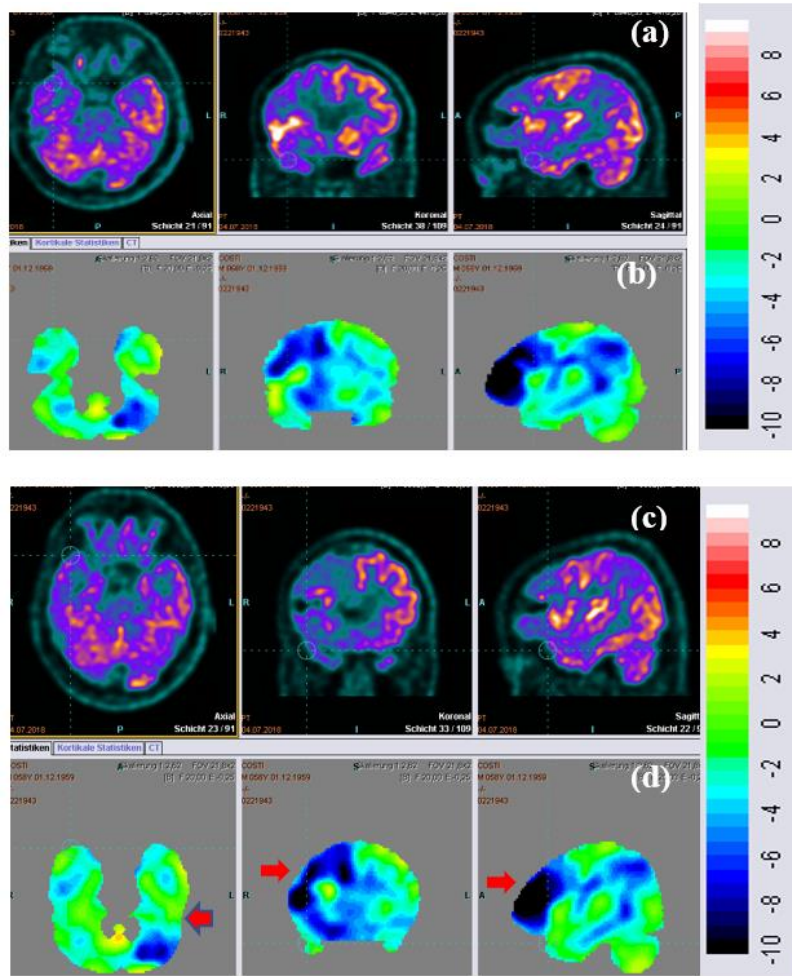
(a) Axial, coronal, and sagittal PET views with attenuation map obtained with nMC-CT attenuation correction, (b) scenium analysis nMC-PET, (c) axial, coronal, and sagittal PET views reconstructed with MC-CT, (d) scenium analysis MC-PET (arrows pointing the differences).
